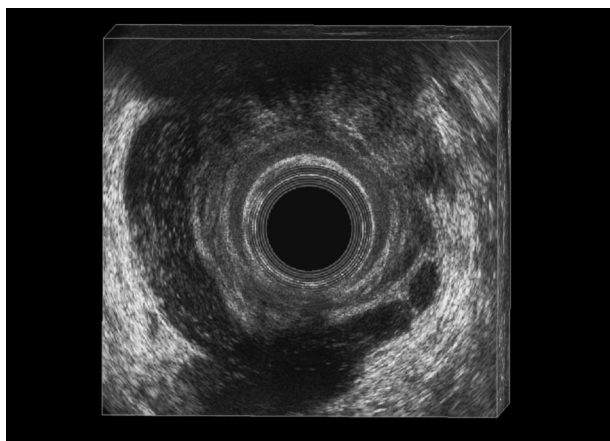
Endoanal ultrasound. Horseshoe supralelevator abscess.
